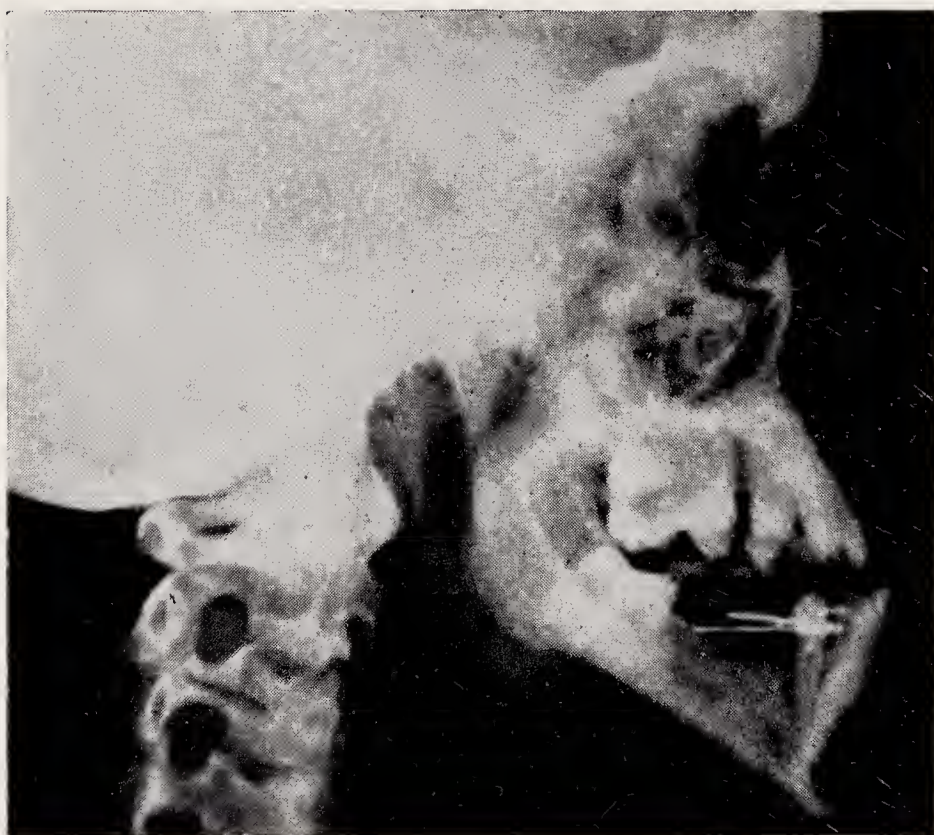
Lateral X-ray of patient, aged 17 years, who sustained severe burns in nasal area when 3 years old. (By courtesy of Mr. N. L. Rowe, Plastic and Maxillo-facial Unit, Rookdown House, Basingstoke.)
